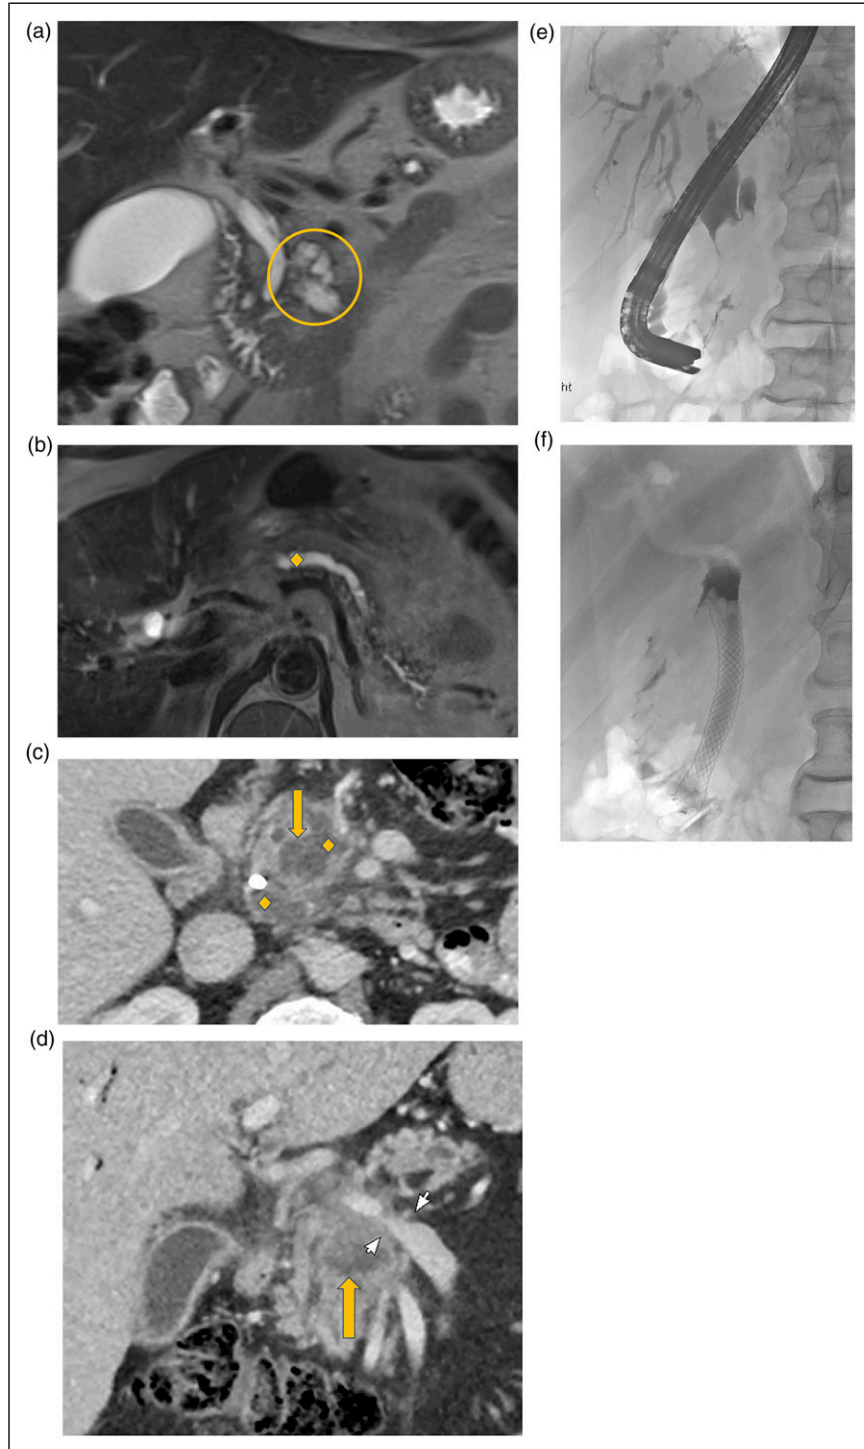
Fifty-seven-year-old male with initial MRI in October 2016 demonstrating a 3.2 cm pancreatic cyst (yellow circle) with distal ductal dilation (yellow diamond), meeting both worrisome features and high-risk stigmata (A-B, Coronal T2 and axial T2 images). EUS-guided FNA showed atypical ductal epithelium/IPMN. Subsequently, the patient presented 12 months later with pancreatitis and jaundice. (C-D) Coronal PV phase CT images demonstrate increased lesion size (yellow arrow), pancreatic and common bile ductal dilation (yellow diamond) with biliary drain in situ, and vascular involvement (white arrows). (E-F) Endoscopic retrograde cholangiopancreatography (ERCP) was performed for brushings and stenting, at which time atypical cells raised concern for malignancy. Following chemotherapy and Whipple's procedure, surgical pathology demonstrated IPMN with invasive carcinoma. MRI: magnetic resonance imaging; CT: Computerized tomography; IPMN: intraductal papillary mucinous neoplasms; FNA: Fine needle aspiration; EUS: endoscopic ultrasound.
